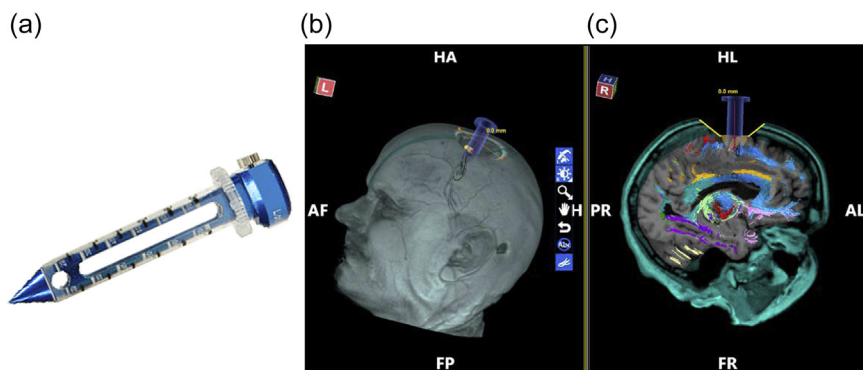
(a) NICO Brain-path[®] instrument for minimally invasive access to brain tissue. The pointed instrument, surrounded by a plastic cannula, is inserted into the sulcus close to the tumor to be removed. Once in place, the central core is removed, and the tumor is aspirated through the cannula that remains in place. (b) Synaptive's BrightMatter[®] planning software maneuvering the cannula relative to a tumor. (c) The BrightMatter platform showing pathway to tumor in relation to the patient's (magnetic resonance imaging) brain and nerve bundles.
